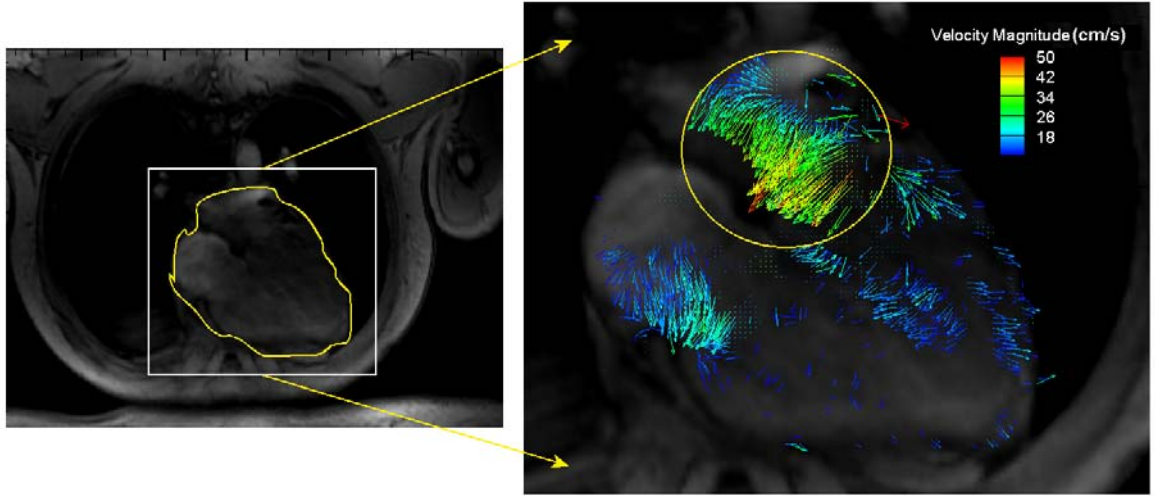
One of the heart image slices at 256x192 resolution obtained using the 4-D PC-MRI system. The vector's color indicate its velocity magnitude.
